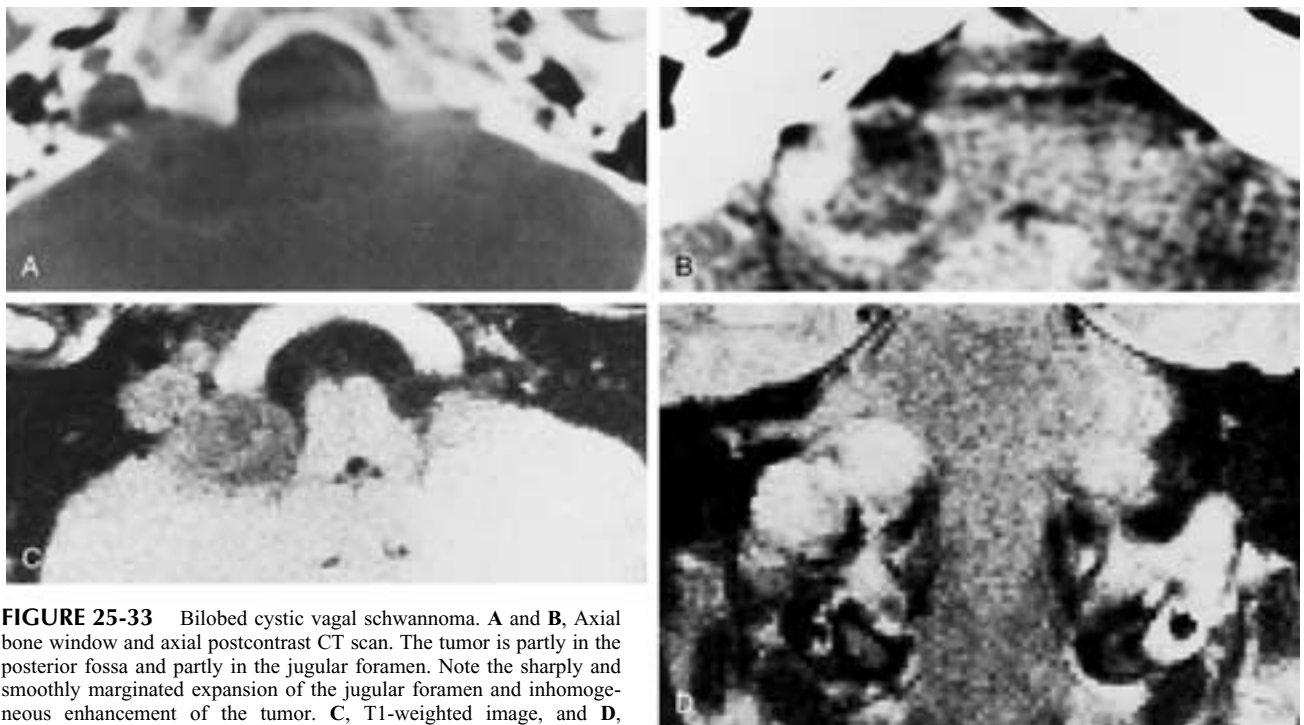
Bilobed cystic vagal schwannoma. A and B, Axial bone window and axial postcontrast CT scan. The tumor is partly in the posterior fossa and partly in the jugular foramen. Note the sharply and smoothly margined expansion of the jugular foramen and inhomogeneous enhancement of the tumor. C, T1-weighted image, and D, T2-weighted coronal image. The tumor is at the pontomedullary level on the coronal image.
